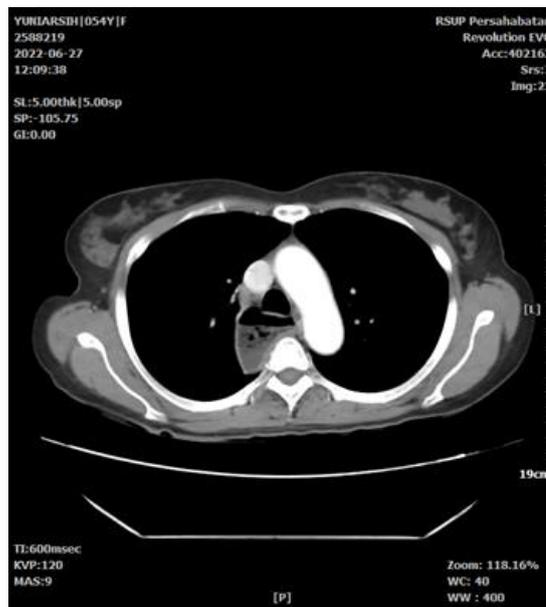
CT scan of the chest revealed dilated esophagus containing food material with air fluid level
